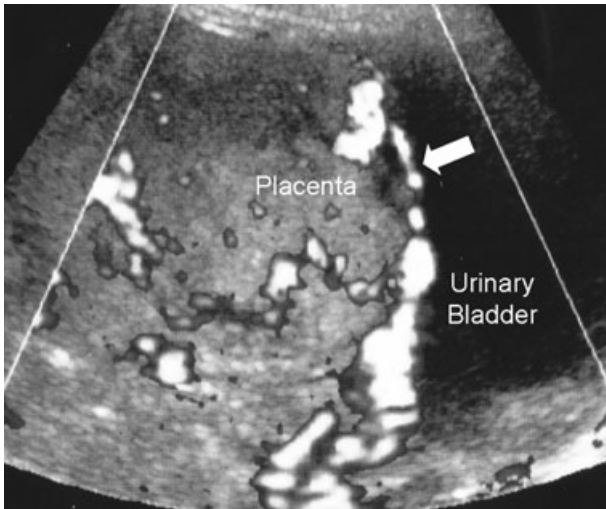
Color Doppler sonography shows dilated and chaotic pattern of vascularization arising from the placenta crossing to the bladder wall, highly suggestive of placental invasion of the bladder.
